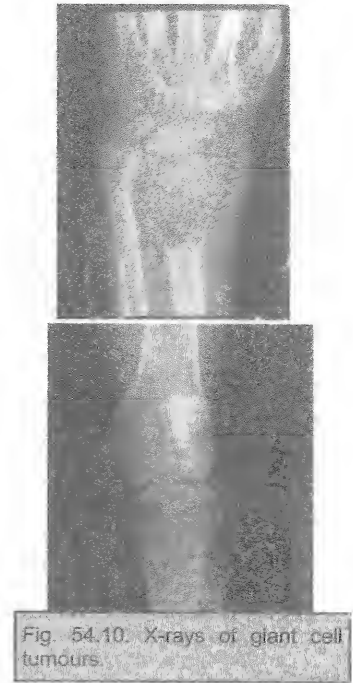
X-rays of giant cell tumours.
